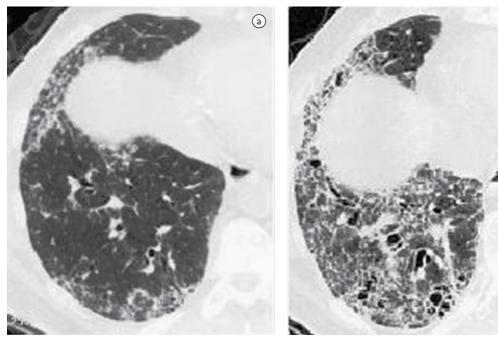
HRCT scans revealing fibrosis progression and lung honeycombing in a patient with idiopathic pulmonary fibrosis.⁽¹⁾
